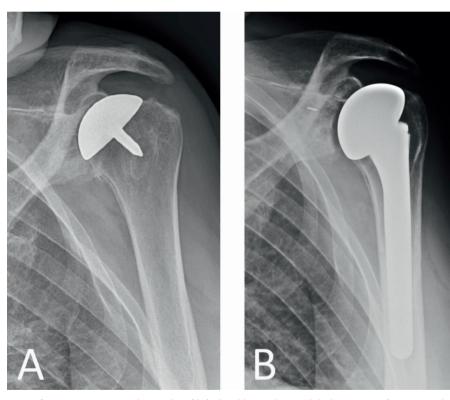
Anteroposterior radiographs of left shoulder with (A) Global CAP resurfacing prosthesis before revision and (B) total shoulder arthroplasty after revision.
